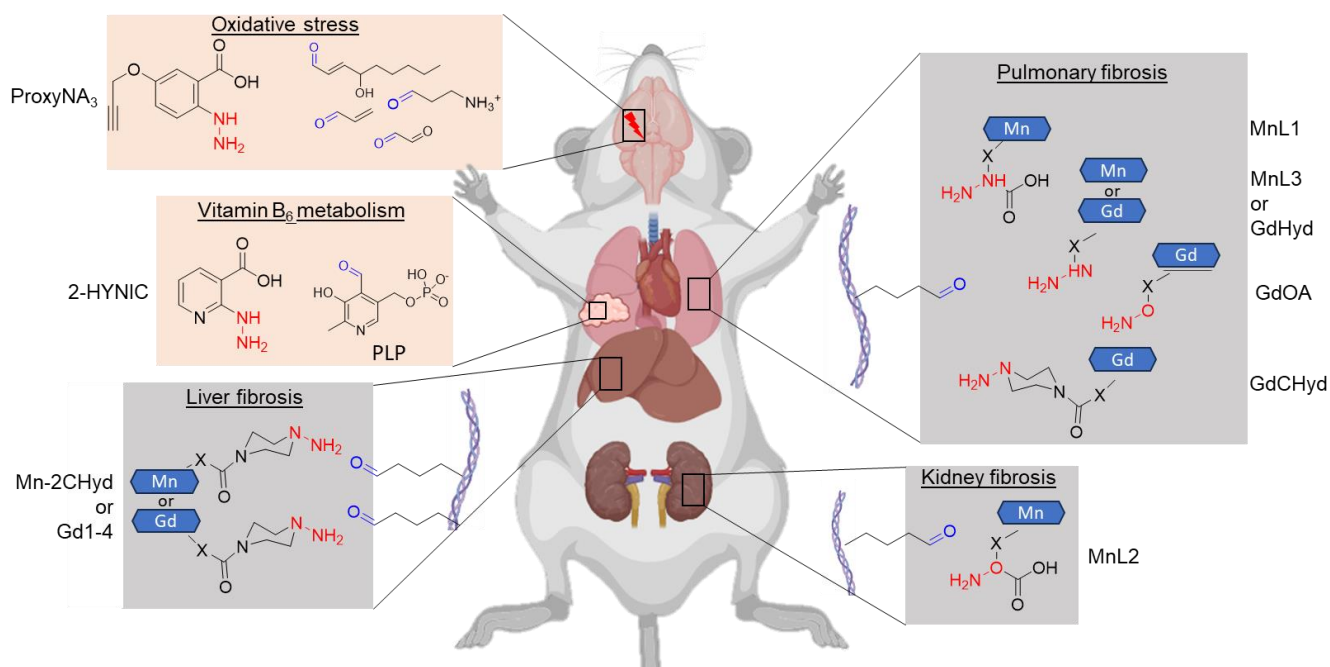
MRI probes for *in vivo* imaging of pathological endogenous aldehydes discussed in this review. These probes are designed to map intracellular (orange) or extracellular (grey) aldehydes *via* covalent binding of the warhead (red) with the targeted carbonyl (blue).
